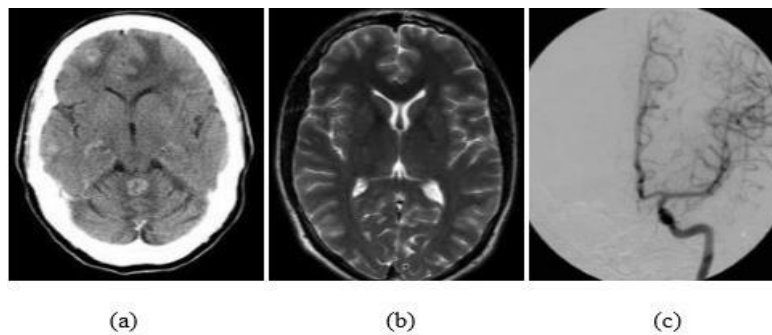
CT (a), MRI (b) and DSA (c) (Zhang *et al.*, 2021).
